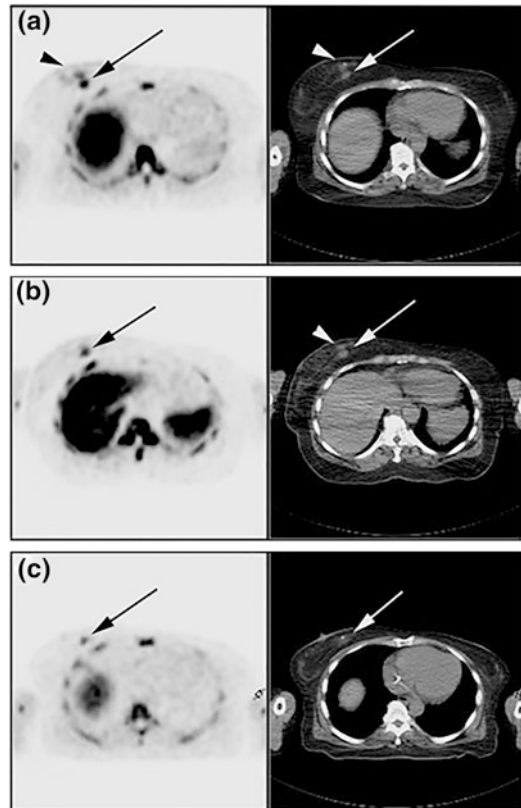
FLT-PET/CT studies at baseline (a), within 1 week of completion of neoadjuvant chemotherapy (b), and after completion of 6 cycles of neoadjuvant therapy and before mastectomy (c). Baseline PET and CT images demonstrate multifocal disease in the right breast (arrows and arrowheads). Followup imaging (B&C) demonstrate progressive decline in uptake. Pathology demonstrated a residual focus of invasive carcinoma, with complete response elsewhere in the breast. Reprinted with permission from (Mankoff et al. 2014)
